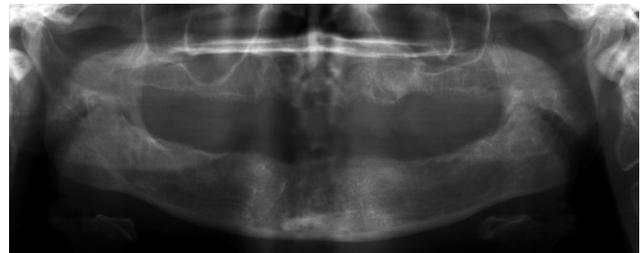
There was no pathology after surgery on the panoramic radiogram
